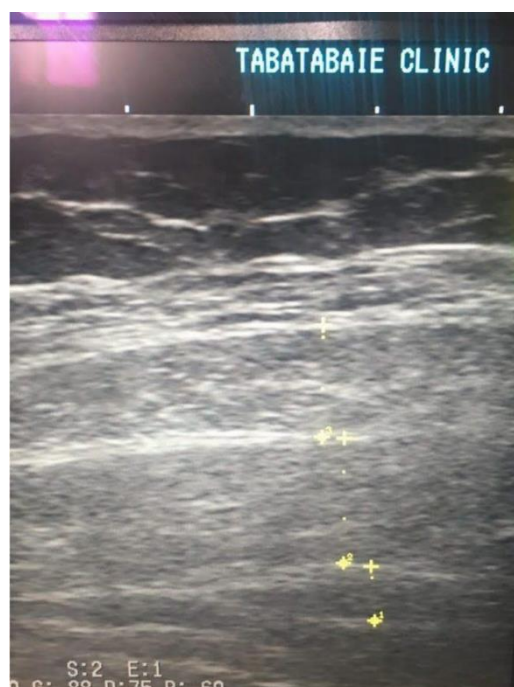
Tra ultrasonography
